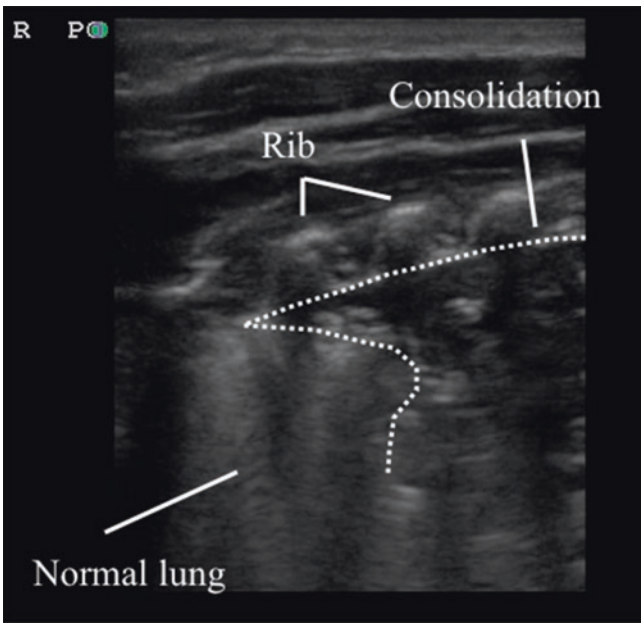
Lung consolidation with sonographic air bronchograms: sagittal view
